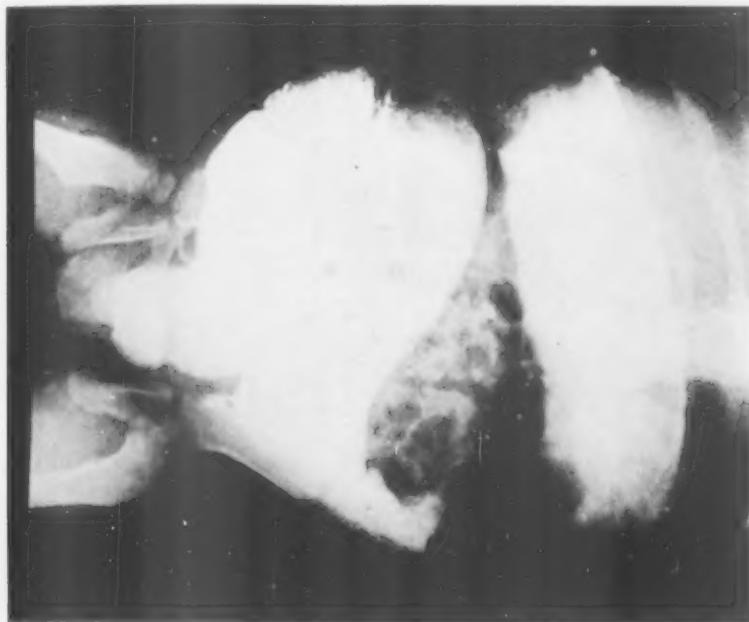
C. T. X-rays of barium enema one month after operation.
